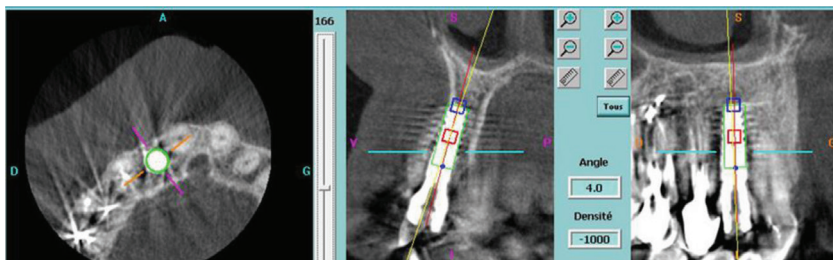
Un CB-CT is made to control the positioning of the implant
